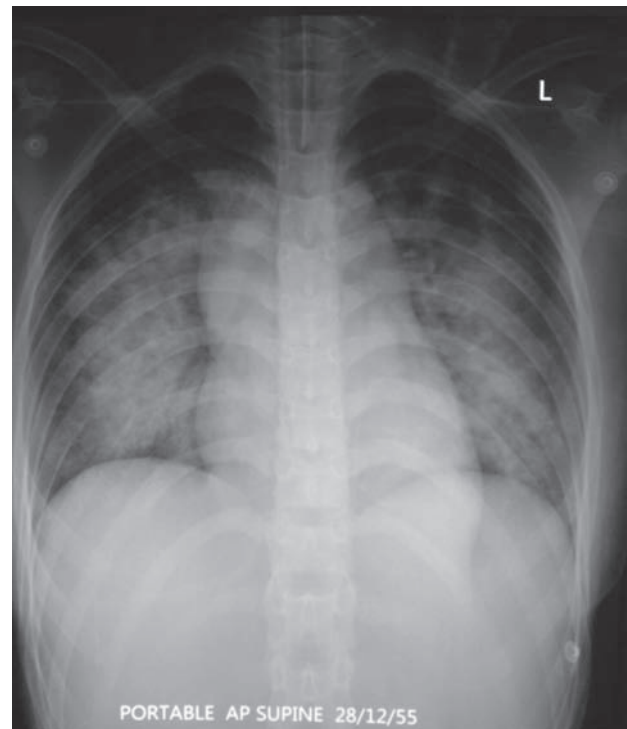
The chest x-ray film showed bilateral perihilar alveolar edema (butterfly appearance).
